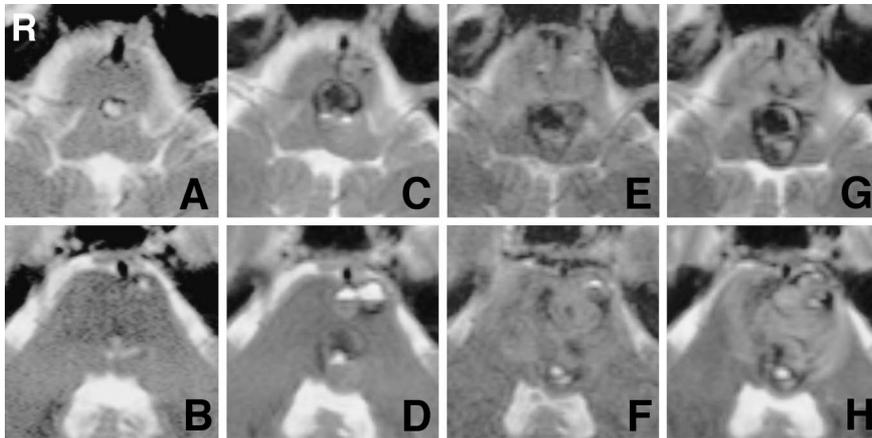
T₂-weighted magnetic resonance images showing the chronological changes in the brainstem cavernomas. A, B: At the initial onset showing two small pontine cavernomas, located in the pontomedullary region and in the anterolateral part of the pons. C, D: At the second episode demonstrating both cavernomas had increased in size. E, F: At the third episode revealing both cavernomas had enlarged with perilesional edema. G, H: Axial images at the fourth event showing the cavernoma in the ventral pons with hemorrhage.
